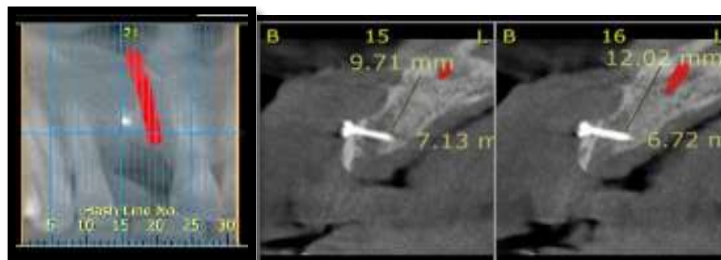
Post-Operative CBCT
